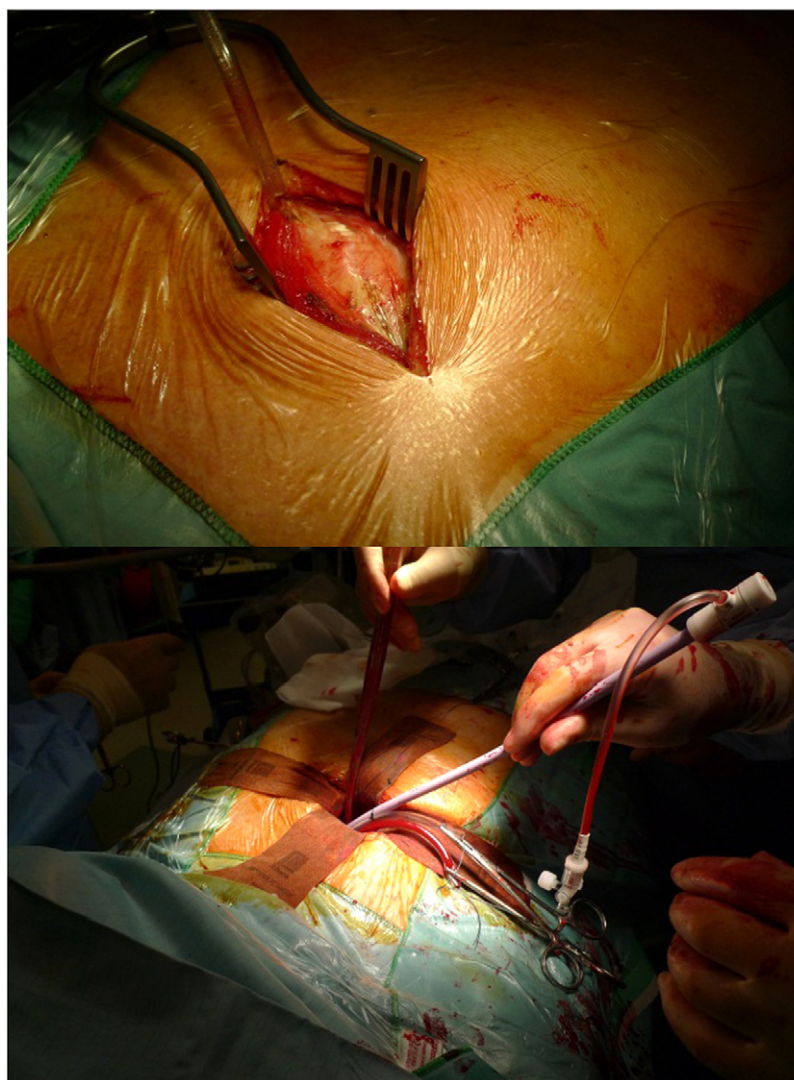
Step-by-step TAVI via direct aortic approach. Top: Right upper parasternal mini-thoracotomy (second intercostal space) with excision of second intercostal cartilage. Bottom: Under direct visualisation, the ascending aorta is directly cannulated with 18-Fr Cook sheath.
